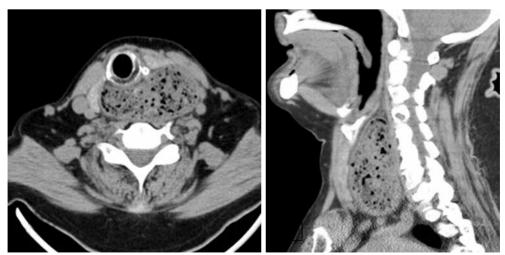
The axial and sagittal sections on computed tomography show the paraesophageal diverticular lesion between the larynx and cervical vertebrae that were displacing the larynx to the right laterally and anteriorly and the left lobe of the thyroid and sternocleidomastoid muscle anteriorly. It was located at the midline, predominantly on the left, and contained food residues.
